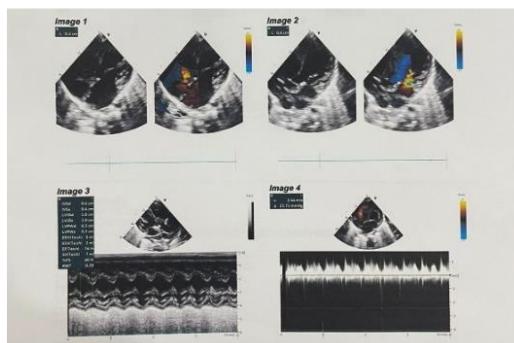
Echocardiogram results of W Hospital (November 6, 2024)
